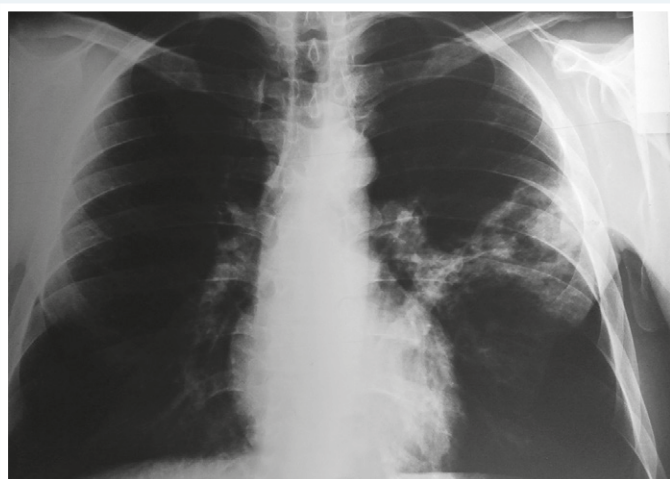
X-ray TCO at hospitalization in the CNE "ZRCDPP" ZRC.
